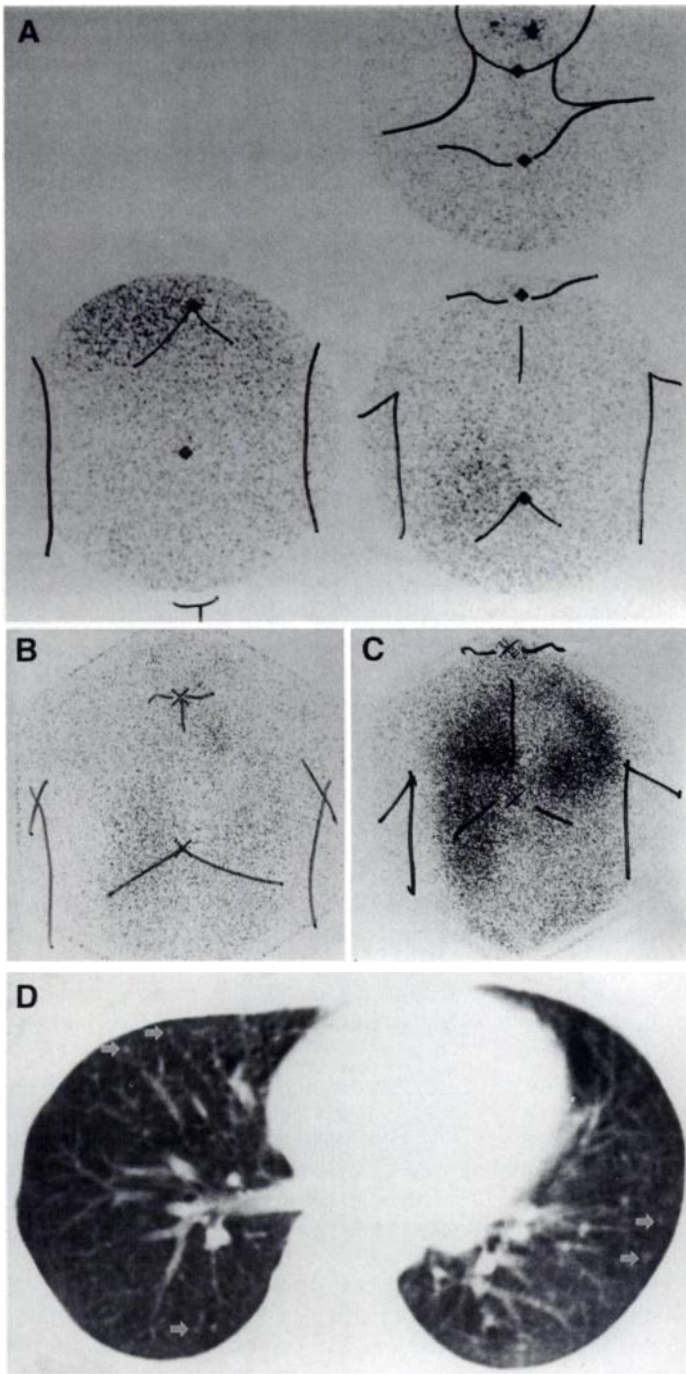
Anterior images of ^{131}I whole-body scan in Patient 2. (A) Whole-body scan showed Grade 2 liver uptake and no metastatic lesion. (B) Whole-body scan 15 mo later revealed faint metastatic lesions in the lung. (C) Whole-body scan after 1 yr showed intense uptake in both lung fields and liver. (D) CT showed hematogenous metastatic lesions in both lungs (arrows).
